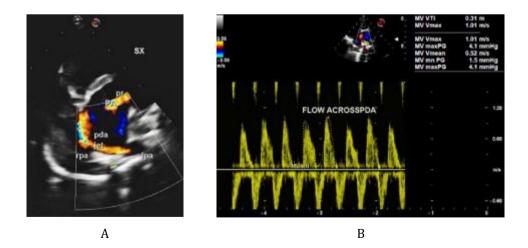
(A) In the SX view, on color flow imaging, a thin jet of PDA is elucidated. The PDA was arising from left pulmonary artery, just after the bifurcation of the main pulmonary artery. The size of PDA was 2.3 mm. (B) On continuous wave doppler analysis, peak/ mean gradient across PDA was 4.1/1.5 mmHg. lpa, left pulmonary artery; rpa, right pulmonary artery; PA, pulmonary artery; pr, pulmonary regurgitation
